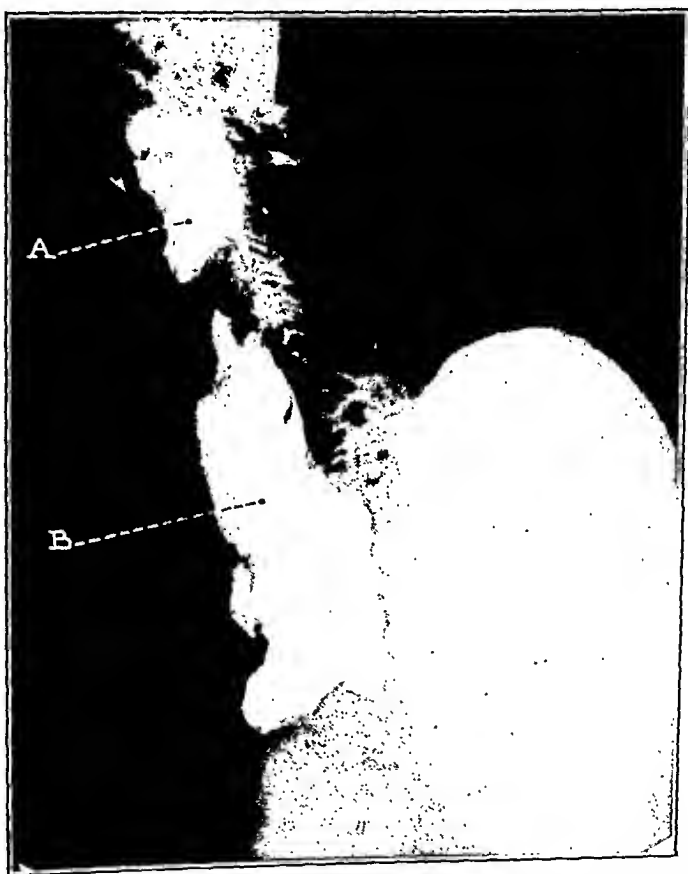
Lateral x-ray of injection of the pretracheal (B) and lateral pharyngeal space (A). Lateral pharyngeal injection is lying in front of the trachea and behind the sternum, and the close proximity of the injection of the lateral pharyngeal and pretracheal can be seen.
